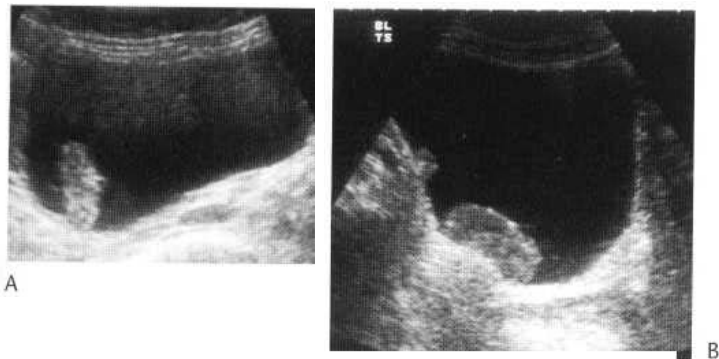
Longitudinal ultrasound of the bladder showing a polypoidal bladder carcinoma (A). Transverse ultrasound of the bladder on a different patient (B) showing two sessile deposits of carcinoma.
